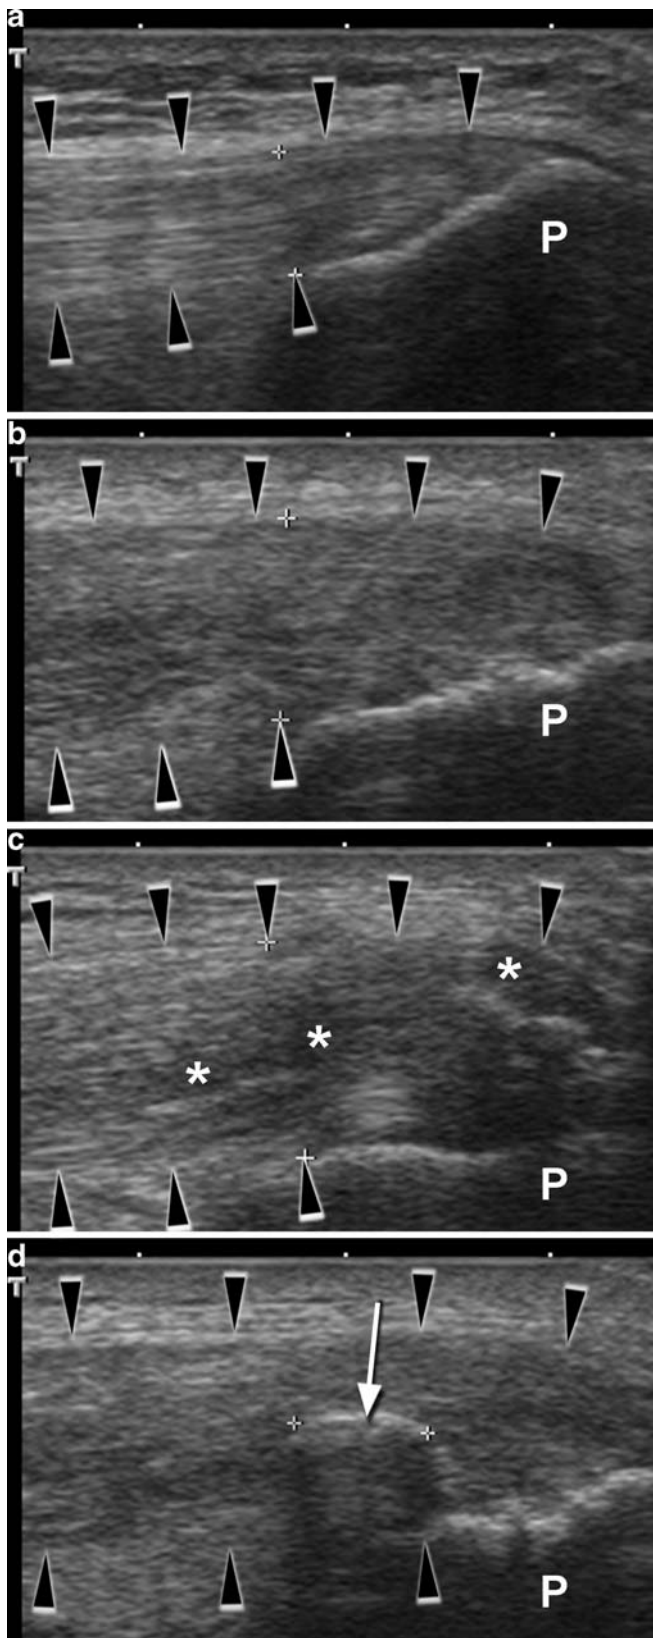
Sagittal sonograms of quadriceps tendons (black arrow-heads): (a) normal, (b) thickening of the tendon and loss of fibre structure, (c) hypoechoogenic foci (asterisk), (a) calcification with acoustic shadowing. (P patella)
